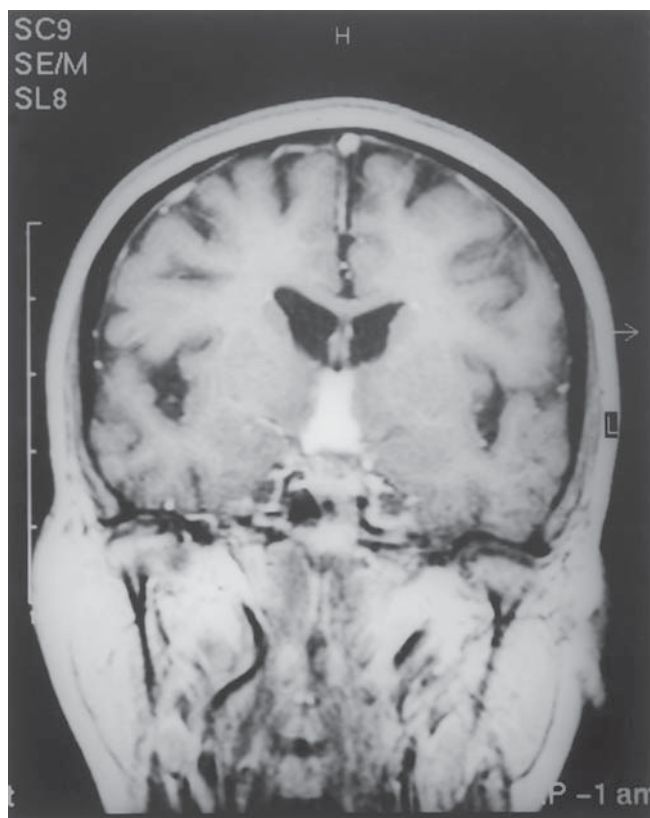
Magnetic resonance imaging (coronal section) showing the hypothalamic lesion encroaching the third ventricle and optic chiasm.
